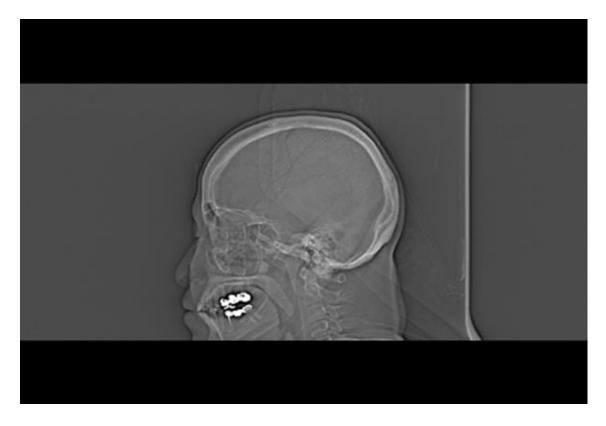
CT scan of the brain (Topogram 0.6 T20s).
